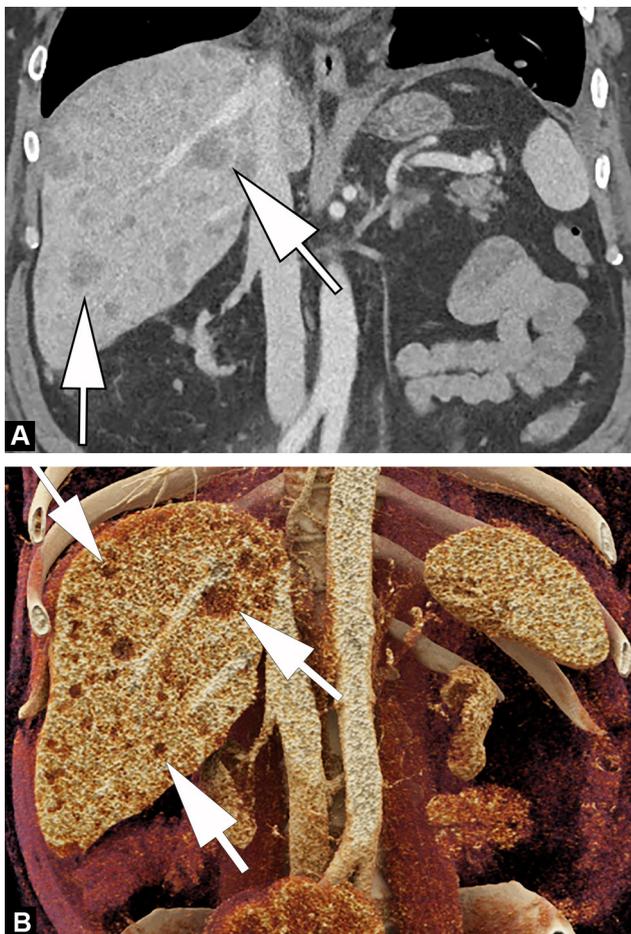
A 45-year-old man with history of metastatic head and neck squamous cell carcinoma. A. Two-dimensional CT image obtained in the coronal plane during the portal venous phase of enhancement shows numerous hypoenhancing liver lesions (arrows), compatible with metastatic disease. B. CT image obtained in the coronal plane during the portal venous phase of enhancement with cinematic rendering can increase tissue contrast and increase the conspicuity of these metastatic lesions (arrows).
